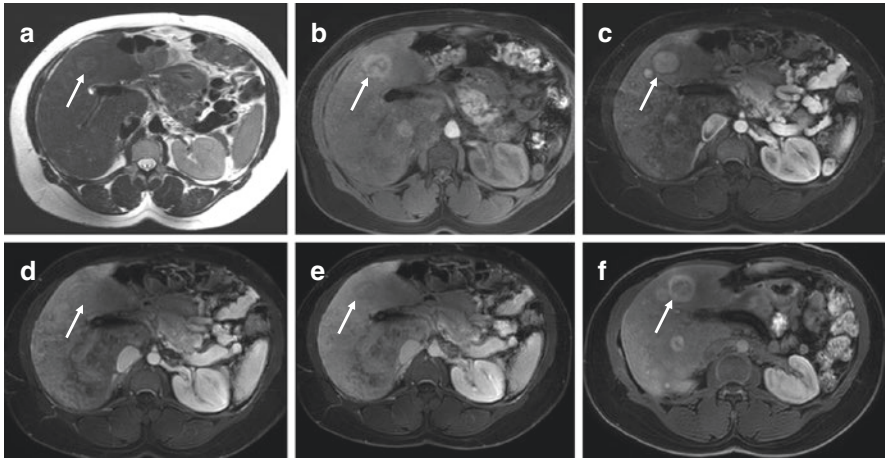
Benign regenerative nodule in a 30-year-old female with chronic Budd–Chiari syndrome secondary to coagulation disorder. MRI shows multiple focal lesions (arrows) with heterogeneous signal intensity on T2-weighted image (a) signal hyperintensity on pre-contrast images especially at the periphery of lesions (b). After liver-specific contrast injection, lesions show arterial phase hyperenhancement (c), but wash-out on portal venous phase and delayed phase images (d–e). This is depicted in one third of benign lesions. Benignity was supported by high signal intensity on hepatobiliary phase images (f), similar to that observed in focal nodular hyperplasia
